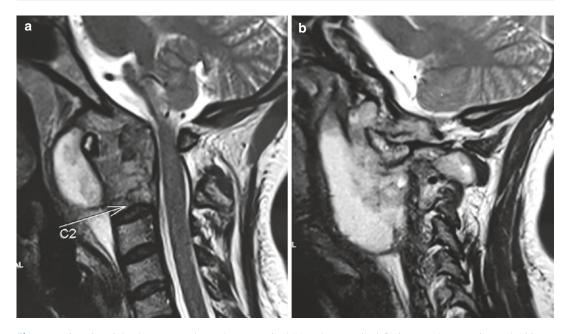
On T2-weighted contrast-enhanced MRI, sagittal (a) and parasagittal (b) images show craniovertebral junction TB with a large prevertebral abscess (Courtesy of S. Behari)
